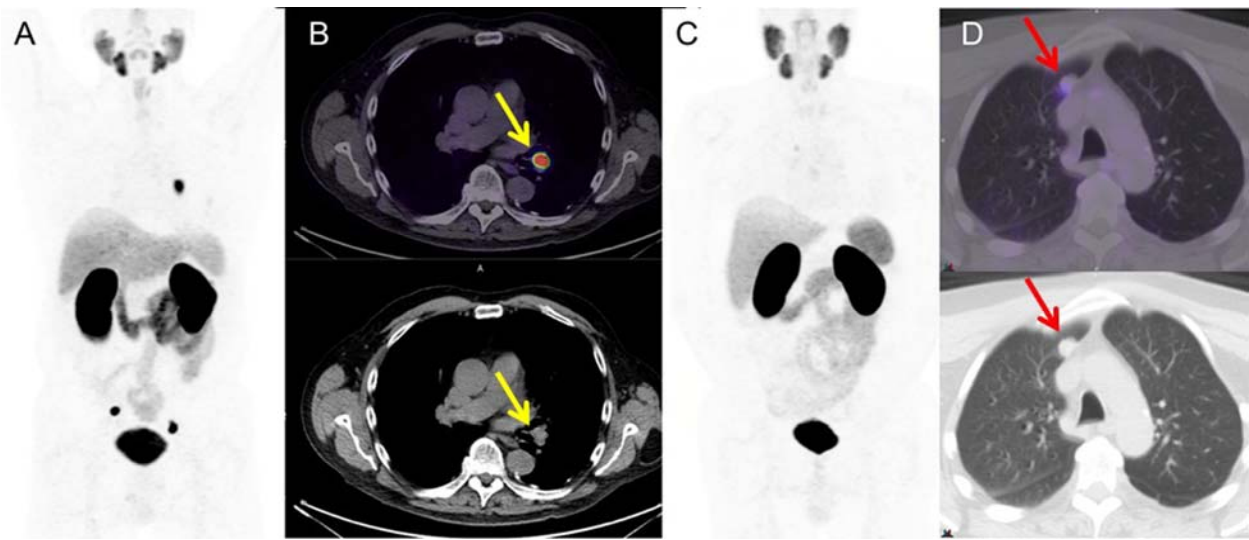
Biopsy confirmed PC examples: (A) and (B), left hilar node (SUVmax 30), (C) and (D), right upper lobe nodule (SUVmax 3).
